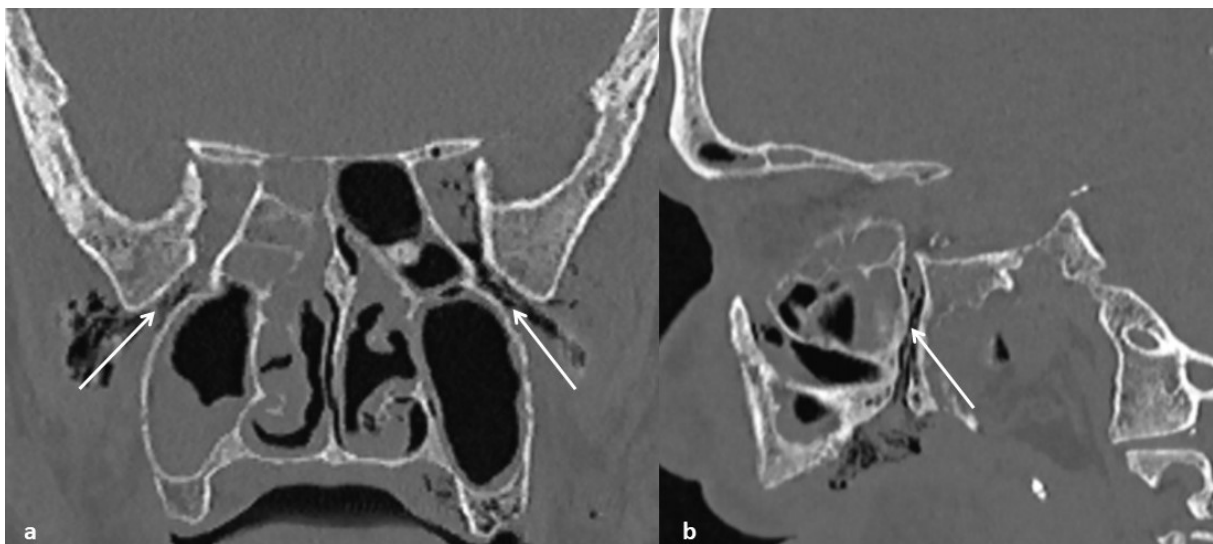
(a) Coronal reformatted CT shows multiple air foci extending from pterygopalatine fossa to infratemporal fossa bilaterally (arrows). (b) Sagittal reformatted CT shows multiple air foci extending from pterygopalatine fossa to oral cavity via the palatine canal (arrow).
